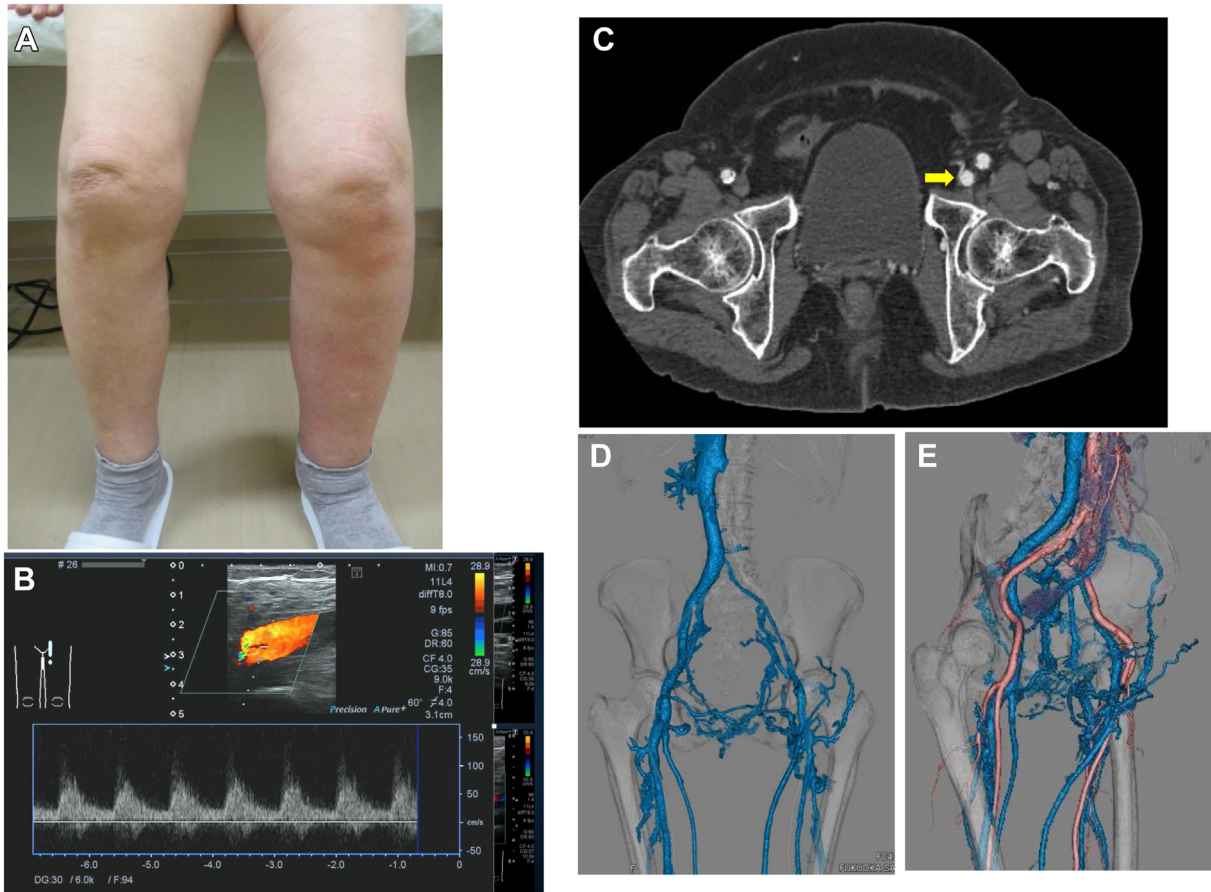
Preoperative clinical data of case 1. A, Photograph of the patient demonstrating left lower extremity swelling and inflammation. B, Duplex ultrasound examination demonstrated an arterialized waveform in the left common femoral vein (CFV). C, Contrast-enhanced computed tomography (CT) showed early opacification of the left CFV (yellow arrow). D, CT angiography three-dimensional (3D) reconstruction (venous phase). Occlusion of the left iliac vein with highly developed collateral vessels. E, CT angiography 3D reconstruction (arterial and venous phase). The exact locations of the arteriovenous fistula (AVF) were not identified.
